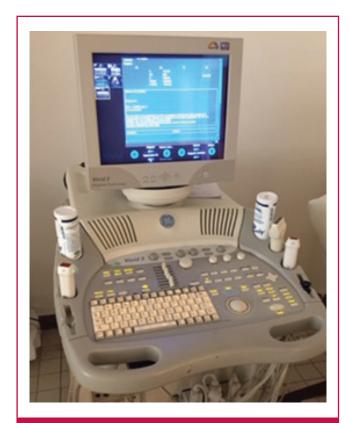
A Vivid3[®] Sonoscape was used for two-dimensional Doppler and M-mode echocardiography.
